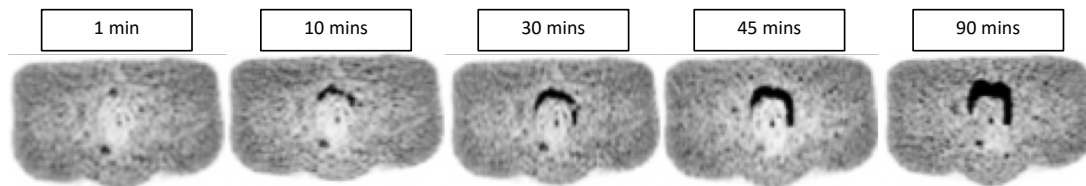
Demonstration of how inaccurate segmentation can limit the accuracy of the background correction technique. This is shown for a single noise realisation, with 4 mm postfilter. All images are displayed with the same maximum SUV threshold value 20.
